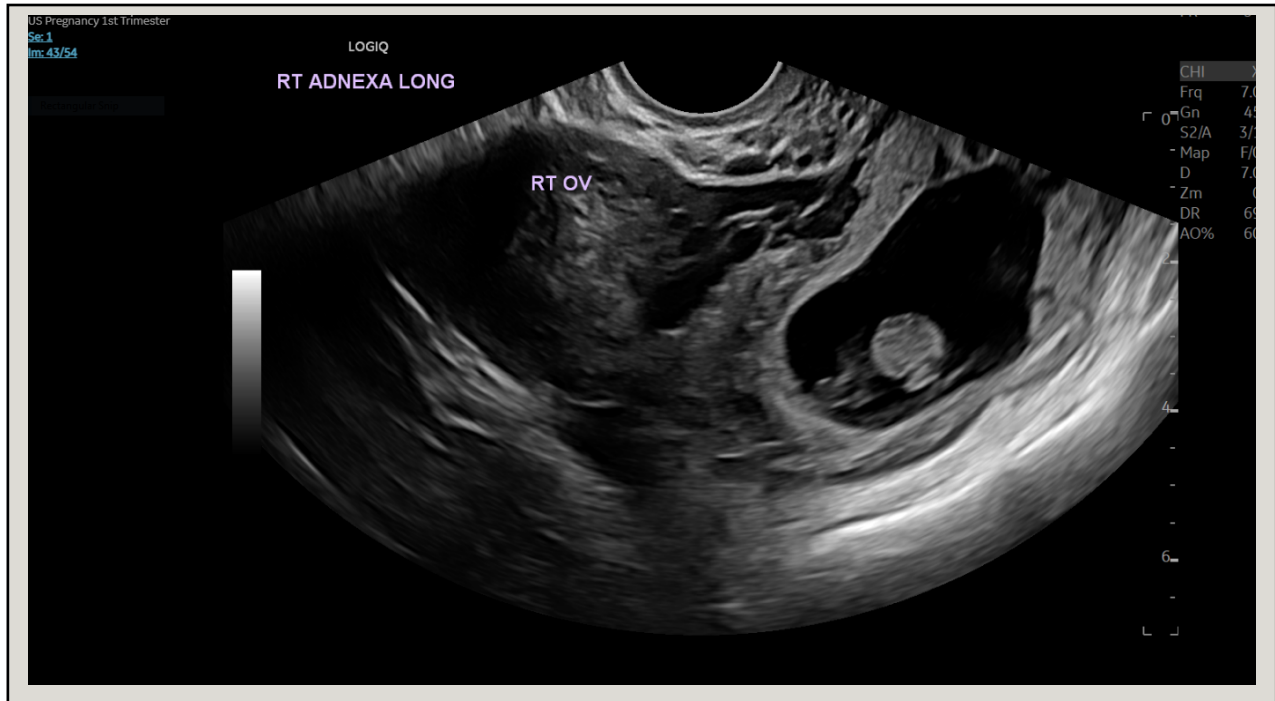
Transvaginal ultrasound showing a right adnexal ectopic pregnancy adjacent to the right ovarian stroma. *Photo taken by Northwest Texas Hospital, Amarillo, Texas.*
